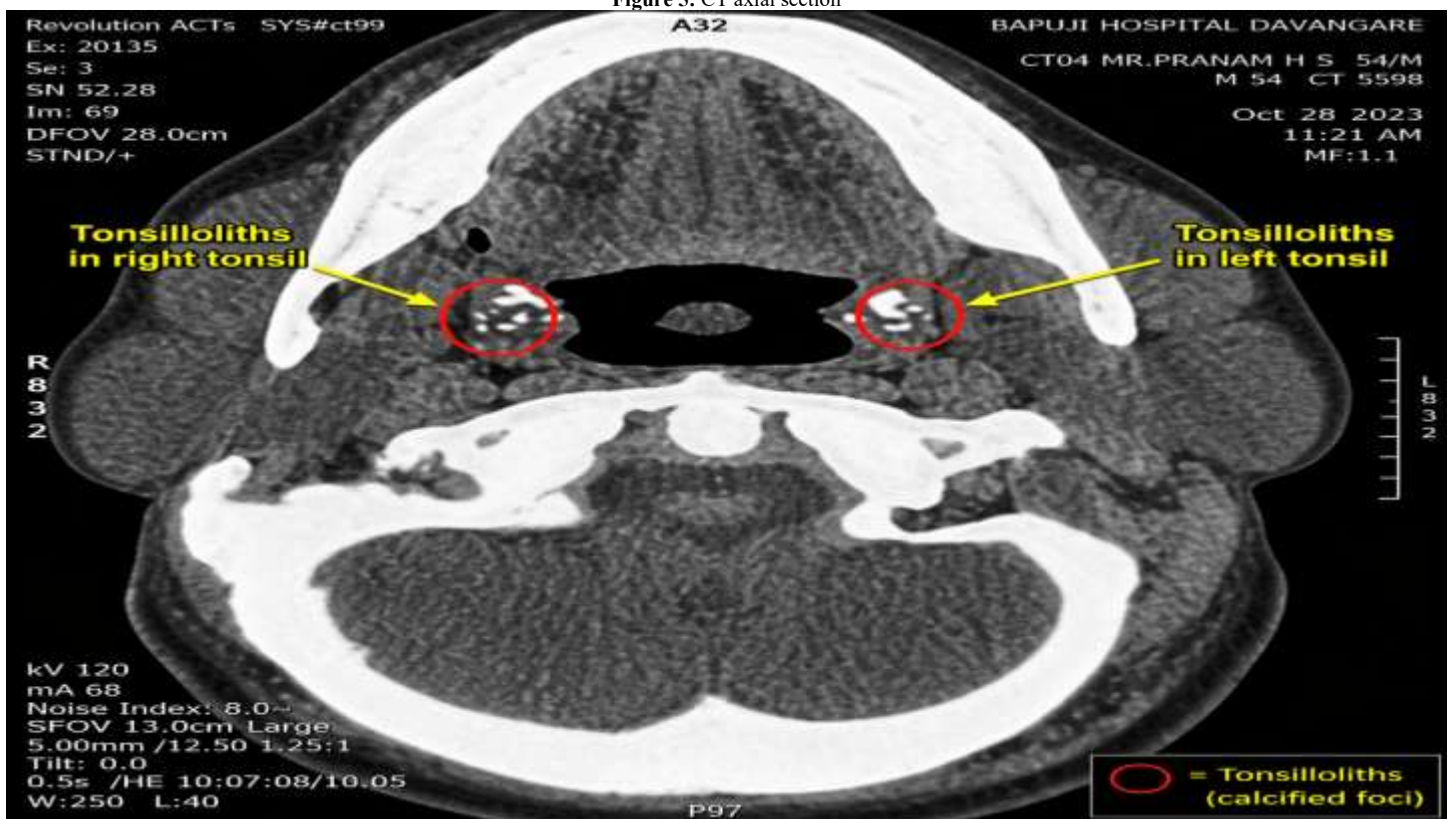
CT axial section
